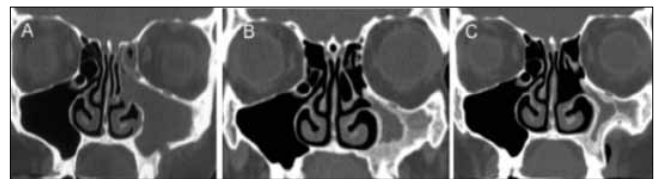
Patient 26. SCDĐT resulting from possible complications in the Caldwell-Luc technique. A) Coronal CT scan after Caldwell-Luc technique and inferior meatotomy for left odontogenic sinusitis; B) Coronal CT scan 7 years after Caldwell-Luc technique showing atelectasis and sclerosis of the left maxillary sinus, hypoplasia and progressive enophthalmos in silent sinus syndrome.
